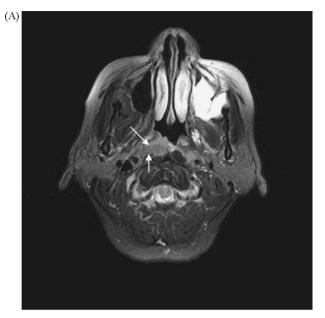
Magnetic resonance imaging showing nasopharyngeal carcinoma (NPC) patients (A) with prevertebral space invasion on T2-weighted image with fat suppression (between arrows) and (B) with Grade 2 parapharyngeal space invasion on T2-weighted image with fat suppression.
